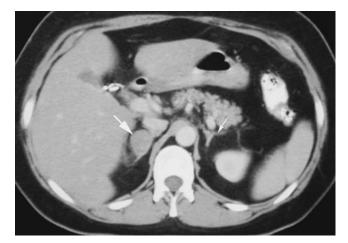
A 46-year-old woman had nonspecific right-sided abdominal discomfort and palpitation. An abdominal computed tomographic scan showed a low attenuation $3 \text{ cm} \times 1.8 \text{ cm} \times 1$ cm right adrenal tumor (*large white arrow*) and a normal left adrenal gland (*small white arrow*). Biochemical workup showed no hyperfunction. She underwent a laparoscopic right adrenalectomy. Pathology showed a 4 cm adrenocortical adenoma.
